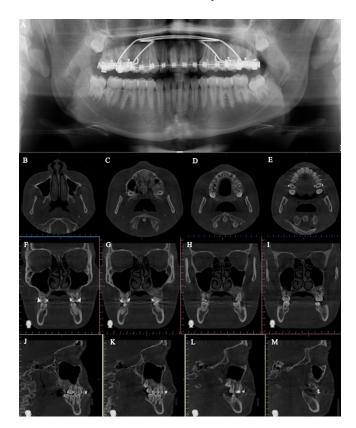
(A) 2023 panoramic radiograph in orthodontic treatment. Bone tissue without alterations. Maxillary sinus mucosa without alterations. CBCT images. (B-E) Axial section shows hyperdense areas with slight asymmetry in the palate in relation to the opposite side. (F-M) Coronal and sagittal section, left maxillary hyperdense areas, without maxillary sinus alterations.
